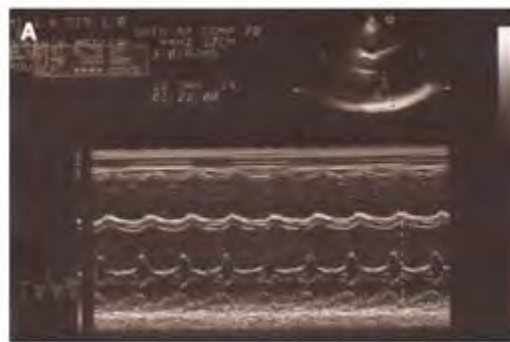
M-mode echocardiography showing a dilated left ventricle and diffuse hypokinetic walls. Source: DOI: 10.4330/wjc.v6.i6.478
